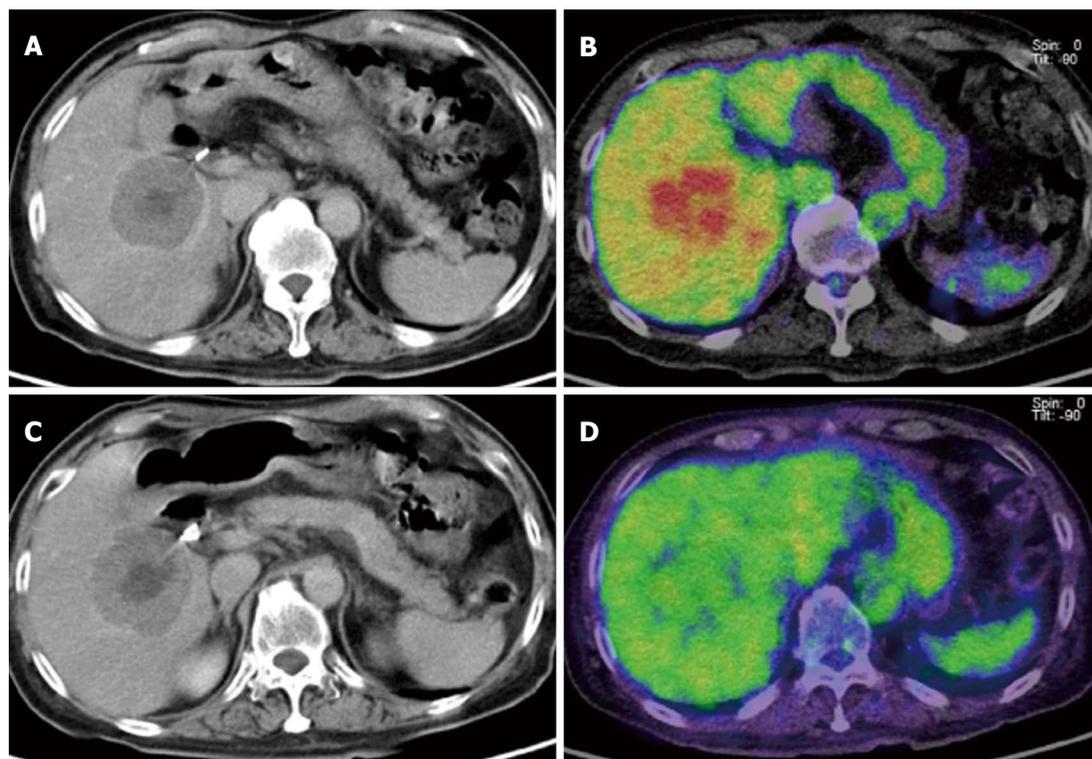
Monitoring therapeutic effect in liver metastases due to GIST gastrointestinal stromal tumor using Gleevec (imatinib mesylate). A, B: Before chemotherapy. A: CECT demonstrated bull's eye like low density in the liver, which was consistent with metastases; B: The metastatic tumor shown as an FDG-avid mass; C, D: After chemotherapy. (C) CECT shows similar mass before chemotherapy although (D) fluorodeoxyglucose (FDG) uptake significantly decreased. FDG-PET may more correctly reflect the therapeutic effect than CECT.
